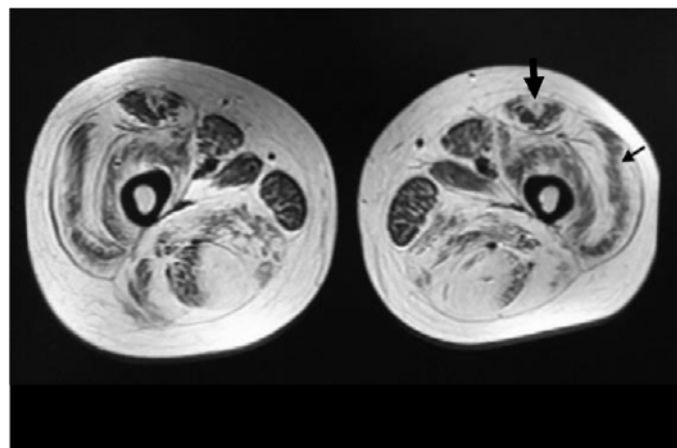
T1 MRI image of proximal thigh muscles demonstrating characteristic tigroid appearance, target (big black arrow) and sandwich (small black arrow) signs due to fat infiltration in dystrophic muscles²⁸.
